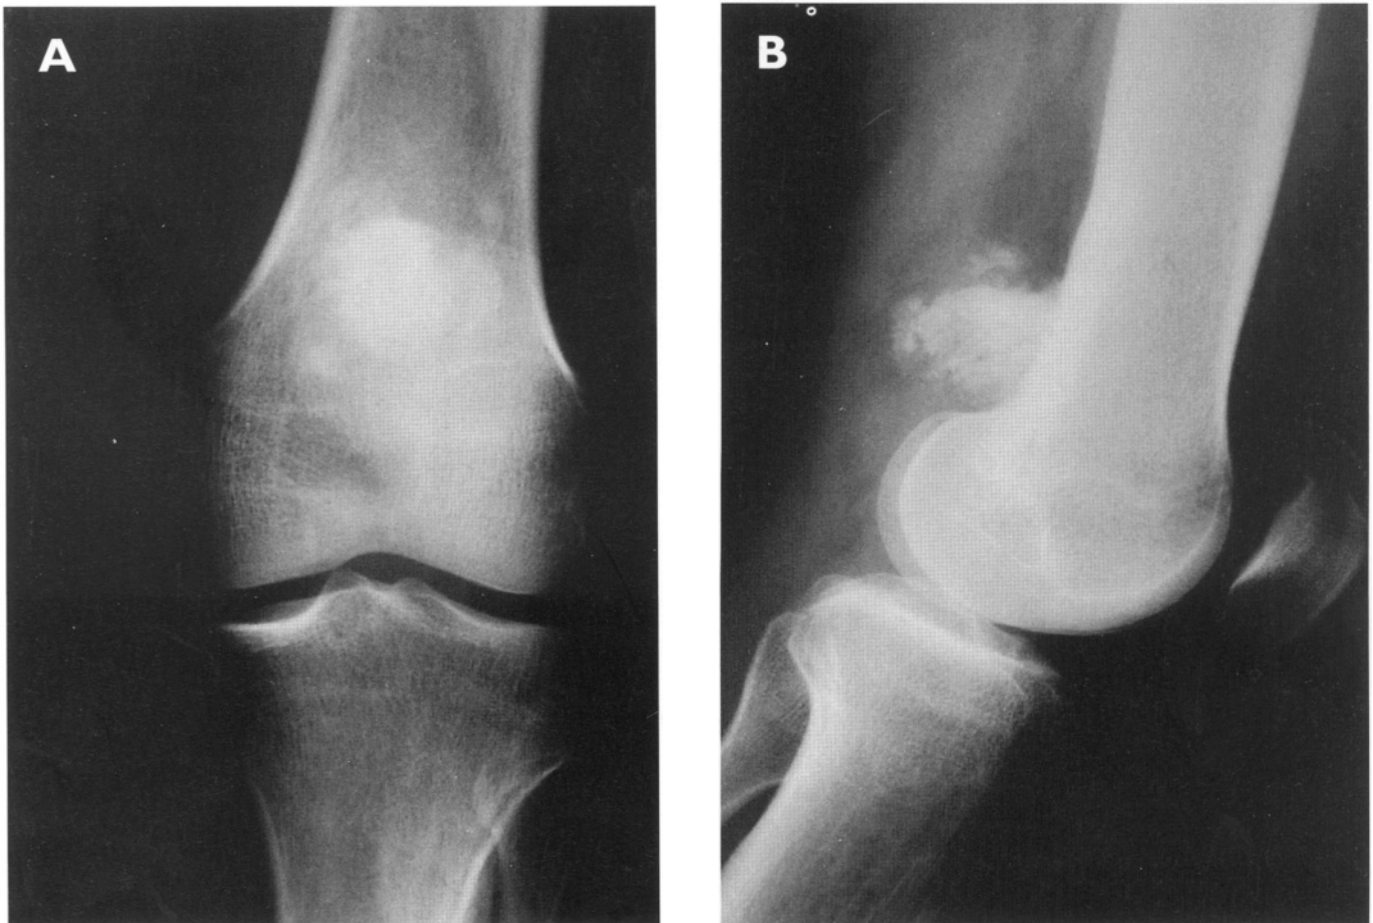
Parosteal osteosarcoma. Plain radiographs of the distal femur, (A) anteroposterior and (B) lateral views, show a dense, irregular, sclerotic lesion, attached to the posterior femoral cortex. The posterior aspect of the distal femur is a classical location for parosteal osteosarcomas and that diagnosis should be considered for any sclerotic lesion in that location.
